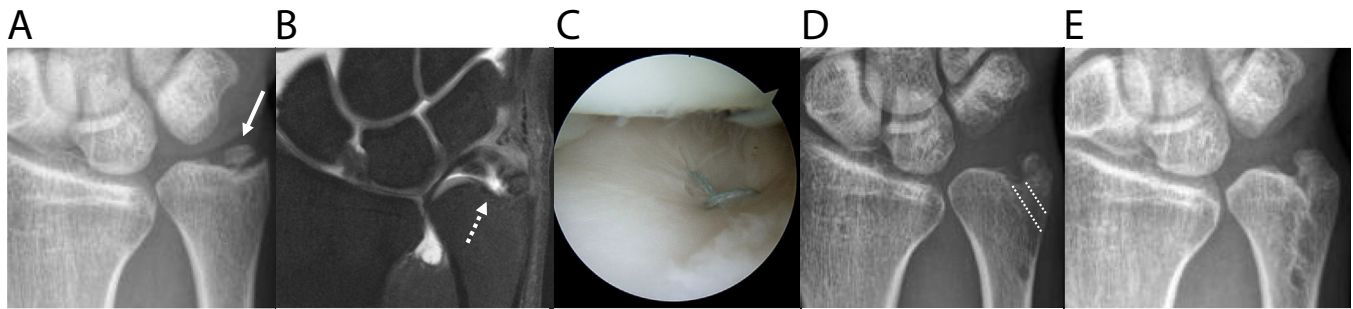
A 31-year-old male patient with TFCC 1B foveal tear and USPFN who underwent arthroscopic transosseous suture repair of the TFCC. (a) Preoperative posteroanterior radiograph with a displaced USPFN (arrow). (b) Magnetic resonance arthrography shows TFCC 1B foveal tear (dotted arrow). (c) Arthroscopic findings after TFCC transosseous suture repair of the TFCC foveal tear. (d) Postoperative posteroanterior radiograph of the wrist with a bone tunnel (dashed line). (e) Postoperative posteroanterior radiograph of the wrist with spontaneous union of the ulnar styloid process. TFCC, triangular fibrocartilage complex; USPFN, ulnar styloid process fracture nonunion.
